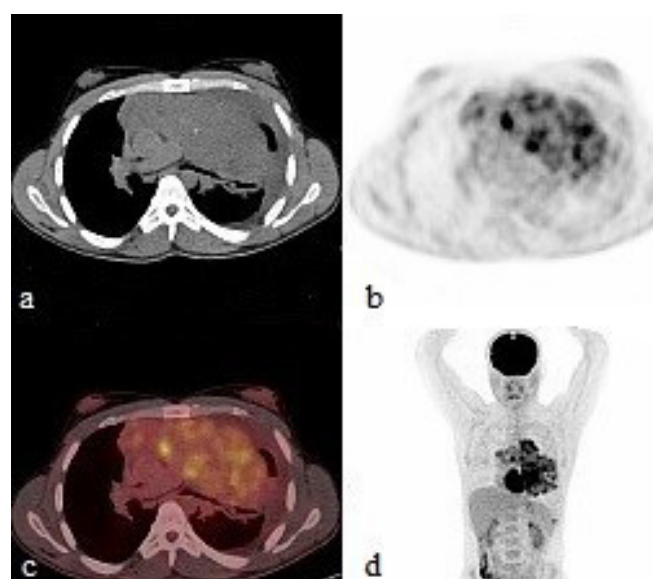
PET/CT demonstrating hypermetabolic anterior mediastinal mass
